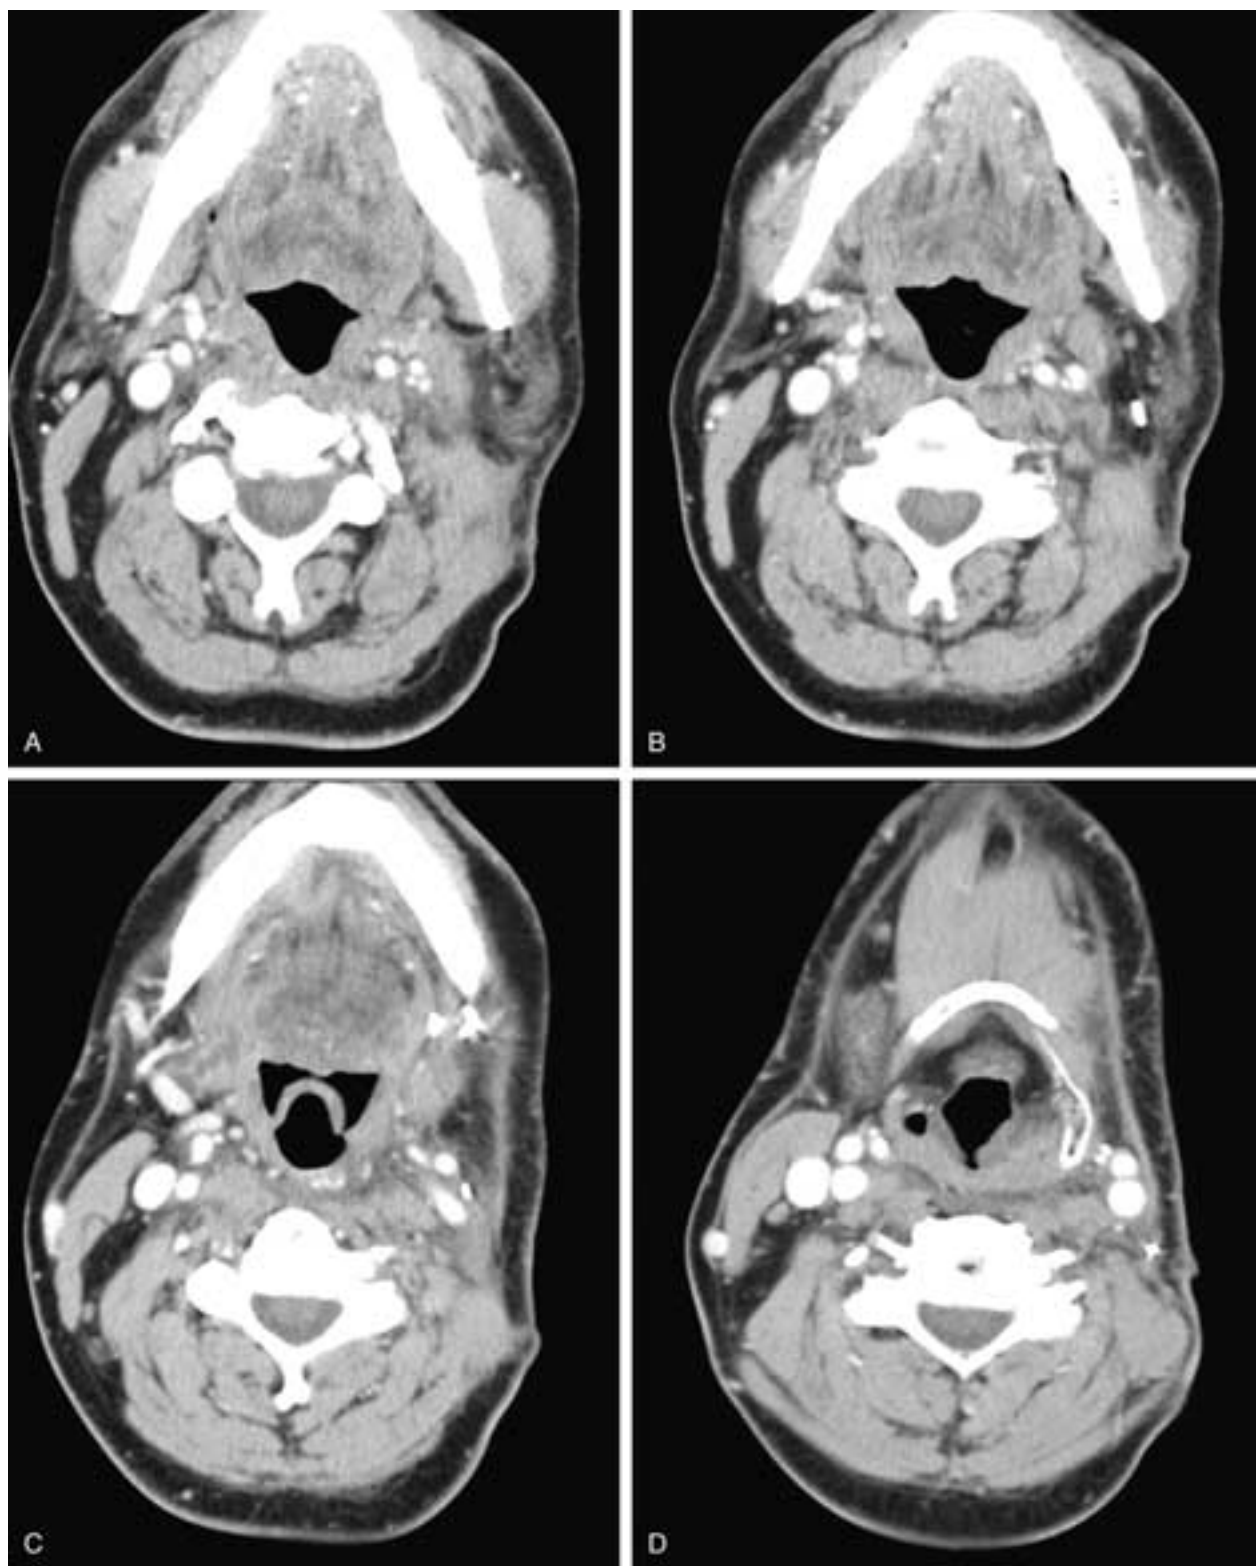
Serial axial contrast-enhanced CT scans from cranial (A) to caudal (F) on a patient who has had a left radical neck dissection. In this patient, the IJV, SAN, and SCM were resected. Note the typical shoulder drop and the beginning hypertrophy of the levator scapulae muscle (*arrow*) in F.
